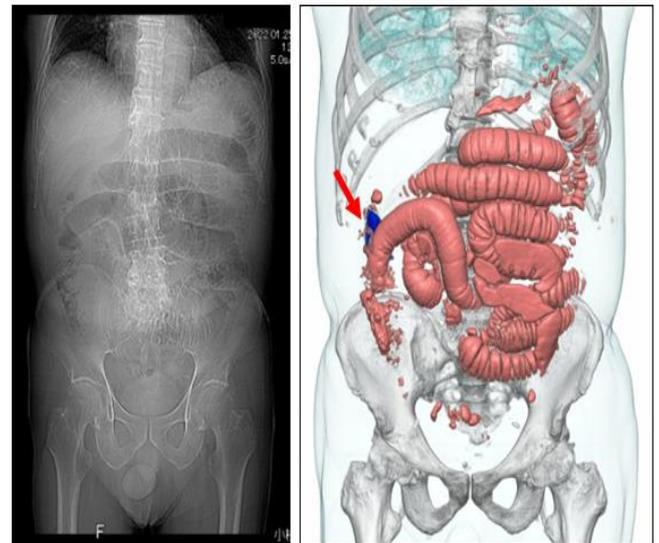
Ileus findings for SBO by rice cake on abdominal X-P and CT reconstruction. 2a: Abdominal X-P can show much gas without the lesion of rice cake; 2b: CT construction shows the image of rice cake (red arrow).
